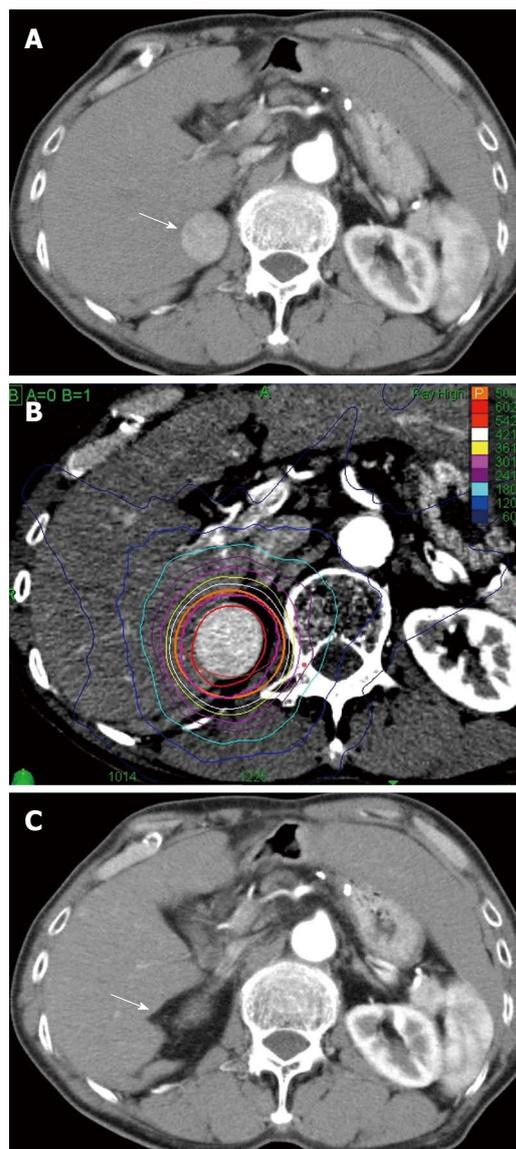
Clinical example of good responder patient by CyberKnife®. A 72-year old male with hepatitis C virus cirrhosis received CyberKnife® therapy at a dose of 50 Gy in 5 fractions for hepatocellular carcinoma sized 28 mm in diameter in S6/7. A: Dynamic computed tomography (CT) scan in arterial phase before the treatment showed a hypervascular lesion in S6/7 (arrow); B: Axial view of radiation dose distribution; C: The lesion did not be distinguished on dynamic CT scan in arterial phase 12 mo after the treatment (arrow). This therapeutic response was described as a complete response.
